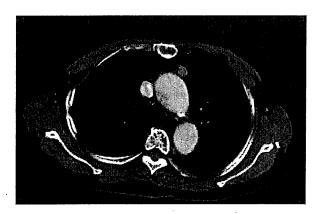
Enhanced abdominal computed tomographic scan showed a well-circumscribed, solid anterior mediastinal mass with heterogeneous contrast enhancement.
